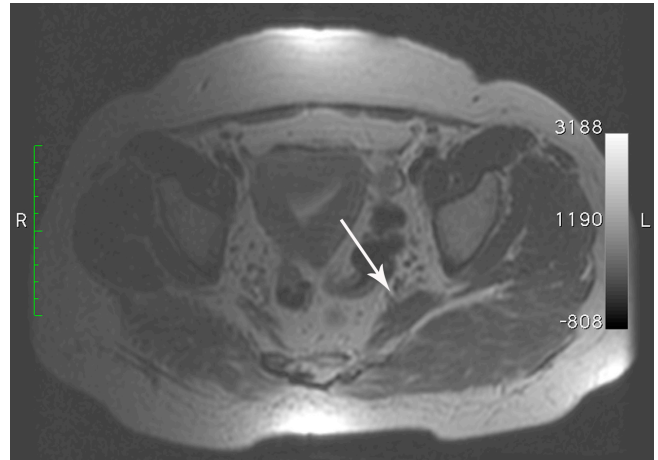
Axial T1-weighted image reveals hypertrophy of the left piriformis muscle and enlarged muscle pressing on the sciatic nerve (arrow).
